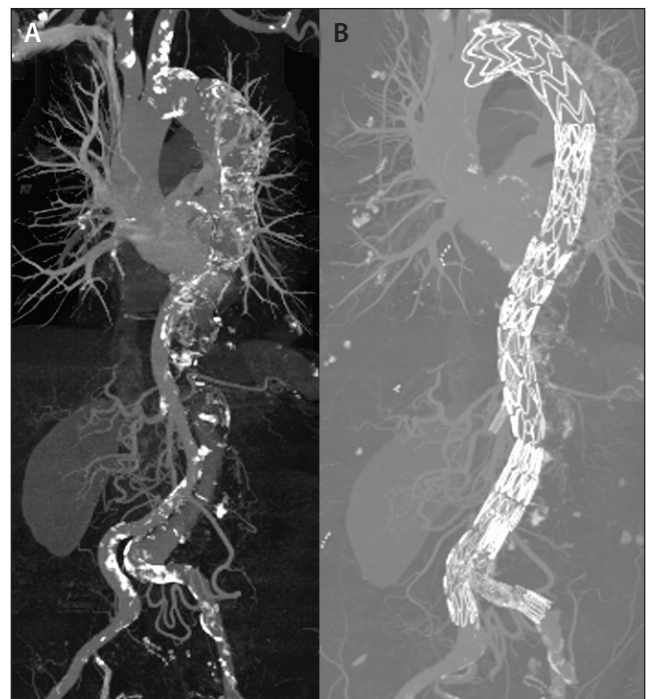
CT angiography (CTA) of a patient with a postdissection thoracoabdominal aortic aneurysm (A). CTA 2 years after endovascular treatment with fenestrated and branched stent grafting showing expansion of the true lumen and shrinkage of the false lumen (B).
